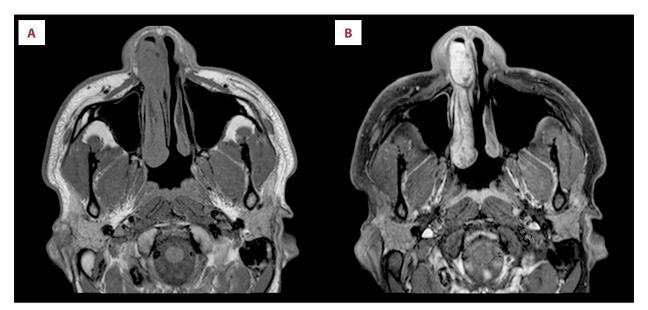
Axial T1-weighted pre contrast (A) and post contrast (B) images show a mass centered at the right nasal vestibule intimately associated with the nasal septum and lateral nasal wall. Post-contrast administration, the mass showed enhancement.
